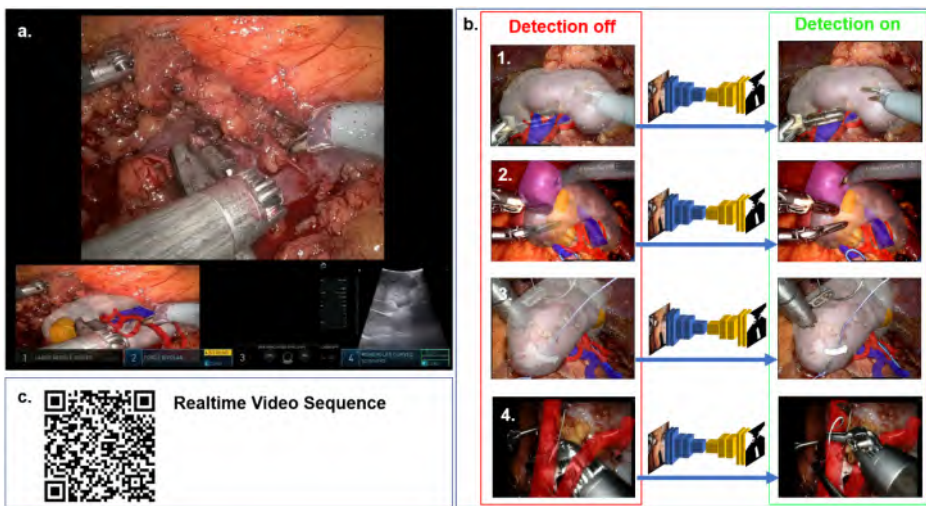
Real-time examples of Augmented Reality Instrument Detection. (A) Depicts the robotic console view as seen during surgery. Here we see the delineation of the monopolar curved scissors, force bipolar and ultrasound probe on top of the 3D model projection in the left TilePro™ window, while the right TilePro™ window depicts the echography image during ultrasound scanning across the tumor. (B) Shows 4 different cases of the increased visualization while the detection is being toggled on. Fig 5.5(b.1) shows the preciseness of instrument detection in RAPN. Fig 5.5(b.2) shows how palpation of cysts and visualization of underlying tumor in A.R. is improved, whilst also detecting the vessel loop. Fig 5.5(b.3) shows how wires, needles, hem-o-lok clips and vessel loops are detected, Fig 5.5(b.4) shows how the technology integrally transfers to RAKT during arterial anastomosis, where the robotic instruments, suture and applied bulldog clamps are detected. (C) Provides a QR code and video link to view the on-off toggling of the AR-ID technology in different cases.
